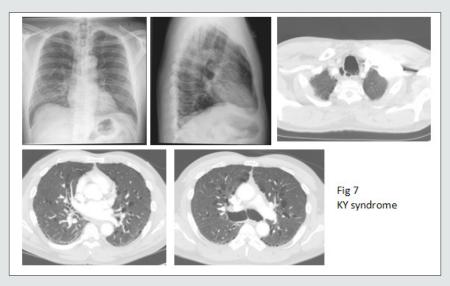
Mounier-Kuhn syndrome, or tracheobronchomegaly, is a rare clinical and radiologic condition. It is characterized by dilation of the trachea/bronchi and multiple para-tracheal and lung cysts. Dilatation of trachea and cysts are better appreciated on CT.
